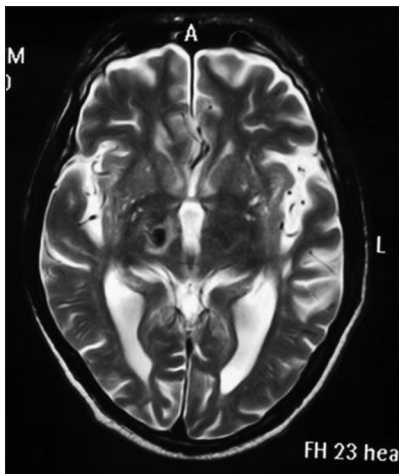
Magnetic resonance imaging showing right thalamic bleed
